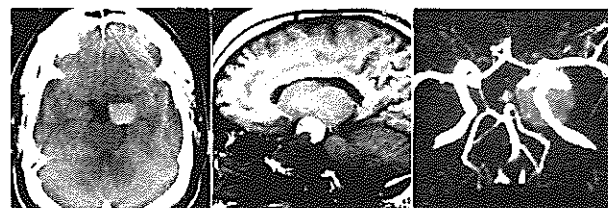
Left: Non-contrast head CT scan showing a left parasellar hyperdense lesion. Center: Non-enhanced T₁-weighted MRI, sagittal section, showing a sellar and suprasellar lesion with a hyperintensity at the superior pole of the lesion which probably represented a subacute clot. Right: MRA showing an increased signal intensity related to the left paraclinoid internal carotid artery.
